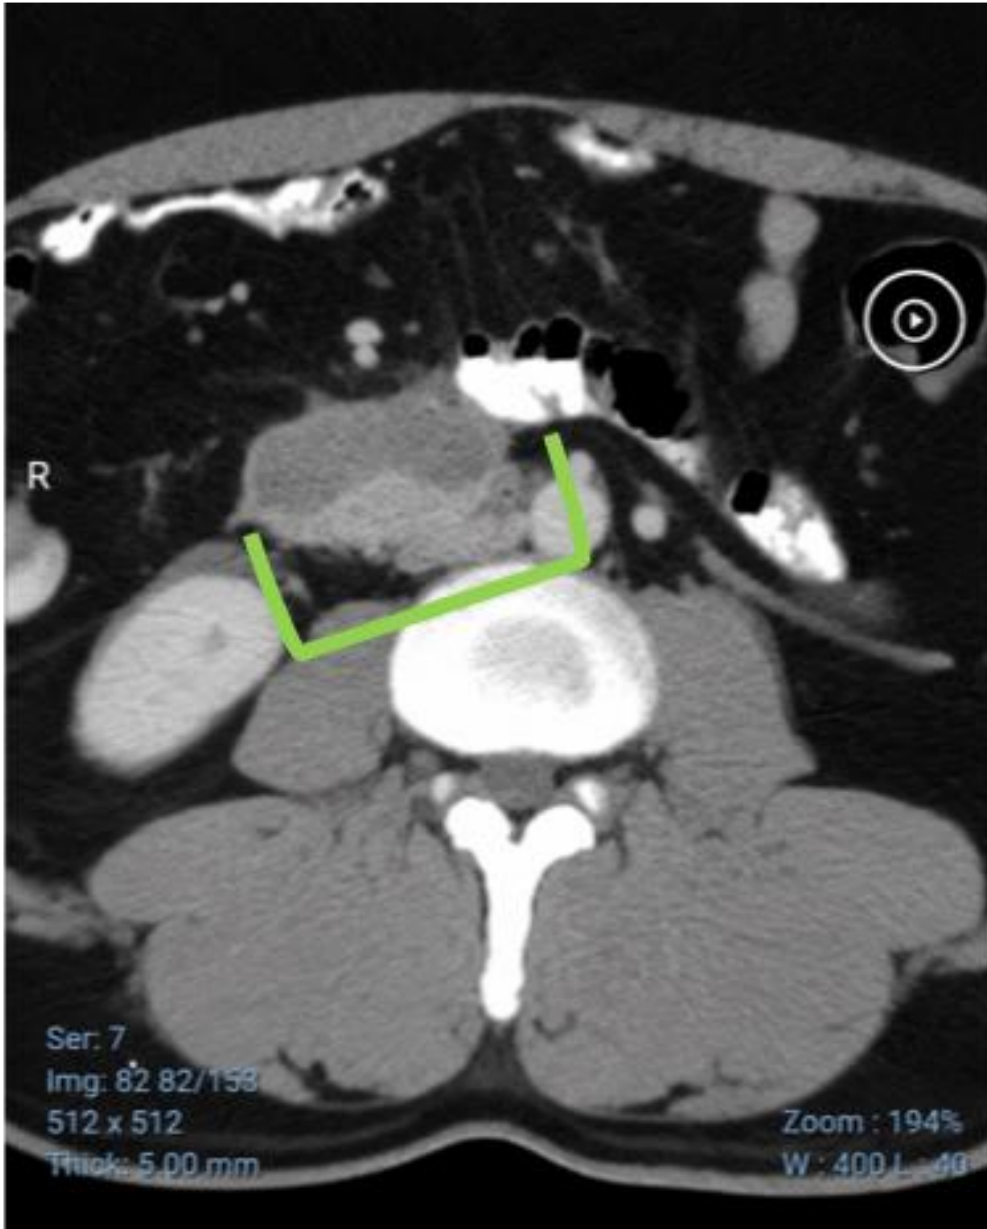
Follow-up contrast-enhanced CT abdomen showing interval reduction in the periduodenal fluid collection and inflammatory changes following conservative treatment.
